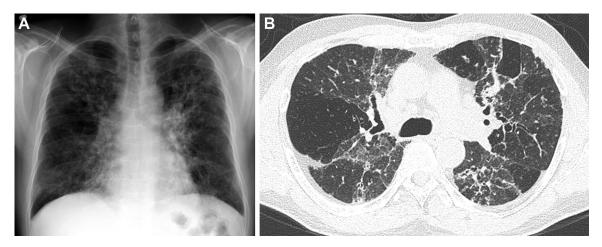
A, Posterior-anterior chest radiograph in a 56-y-old man with history of chronic hypersensitivity pneumonitis showing hyperinflation, patchy hyperlucency, coarsened markings, and central fibrotic opacities. B, HR CT image in the same patient showing mosaic attenuation and patchy ground-glass and reticular opacities typical for chronic hypersensitivity pneumonitis. See Figure 24 legend for expansion of abbreviations.
